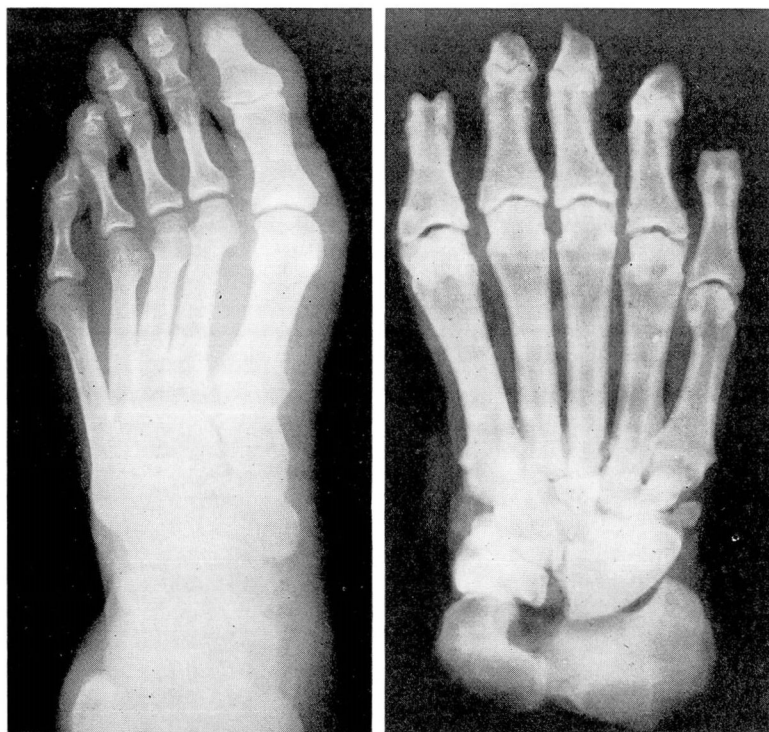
(b) Radiograph of human foot, left, and bear paw right, both of the left foot (human dorsal view, bear plantar view).
